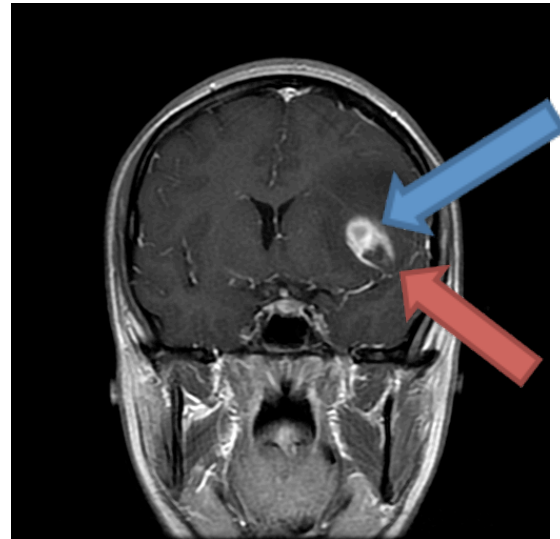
Repeat coronal MRI with the blue arrow pointing to the original lesion and the red arrow pointing to the new lesion.
